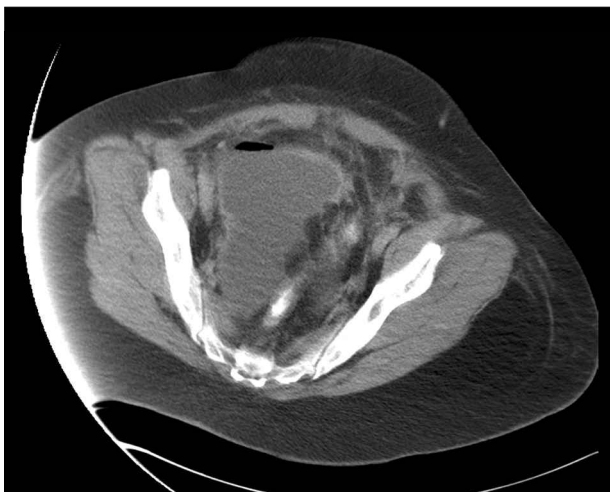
Large right pelvic abscess on CT scan.
